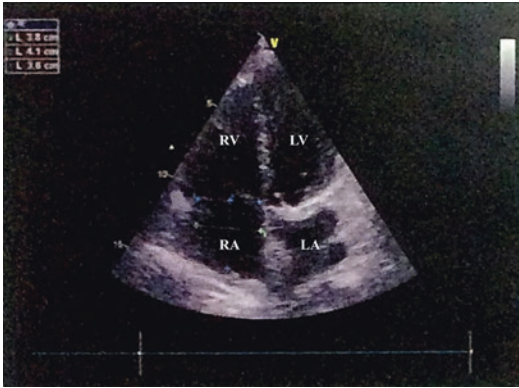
Postoperative *echocardiogram*
